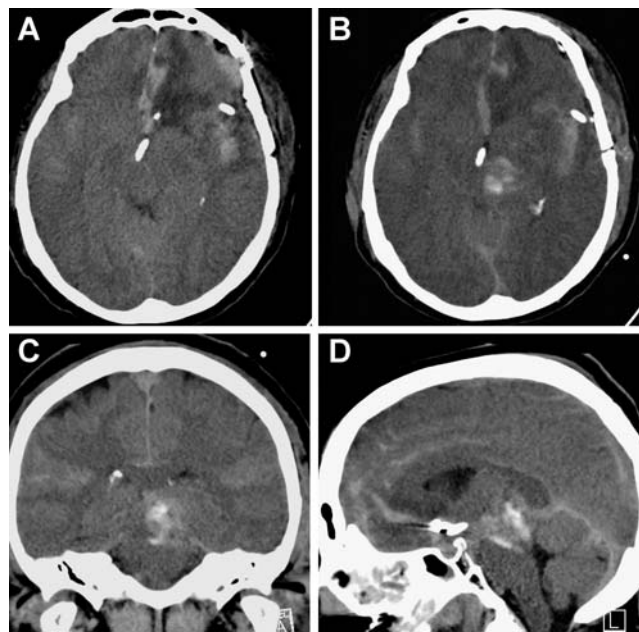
Immediately after IAP, a new hyperdense lesion is noted in the left mesencephalon without crossing of the midline (b, c, d) when compared to the CT before the procedure (a). Note the absence of a significant mass effect as one would expect in the case of hemorrhage. Furthermore, no vessel rupture or extravasation of contrast dye was noted during the procedure. The Hounsfield units (55 to 110) of more than 100 suggest that also part of the contrast dye contributes to the extravasation
